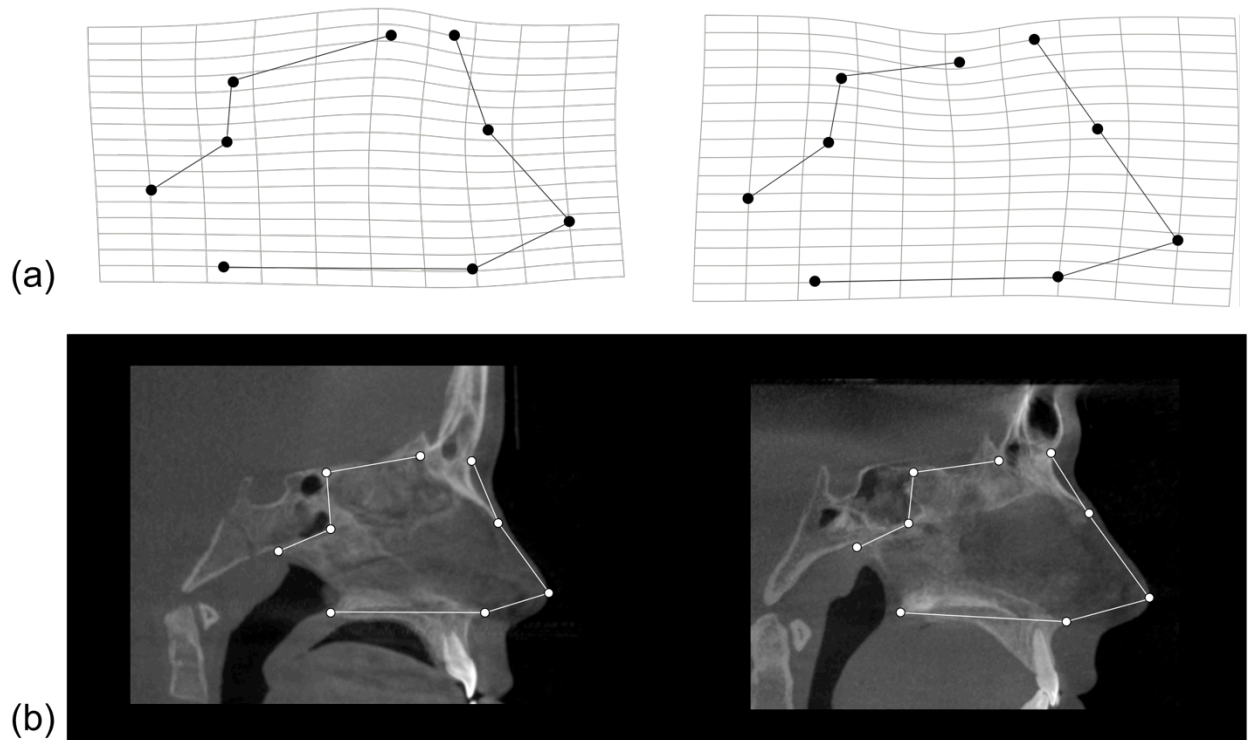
Allometric shape variation. (a) Thin plate splines and wireframe models representing the range of shape variation correlated with centroid size. The spline and wireframe model on the left represents shape associated with smaller centroid values (i.e., younger individuals), while the spline and wireframe model on the right represents shape associated with larger centroid values (i.e., older individuals). (b) Midsagittal cone beam computed tomography images of individuals spanning the range of centroid size values from small (left) to larger (right).
